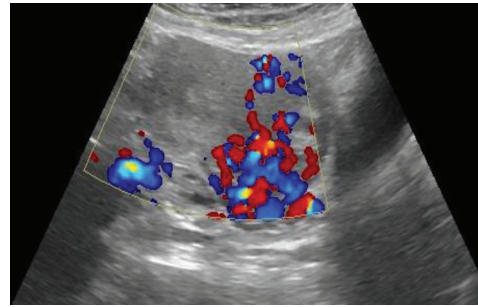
(C): Colour Doppler ultrasound images revealed tubular anechoic lesions with markedly raised vascularity with turbulent flow.
